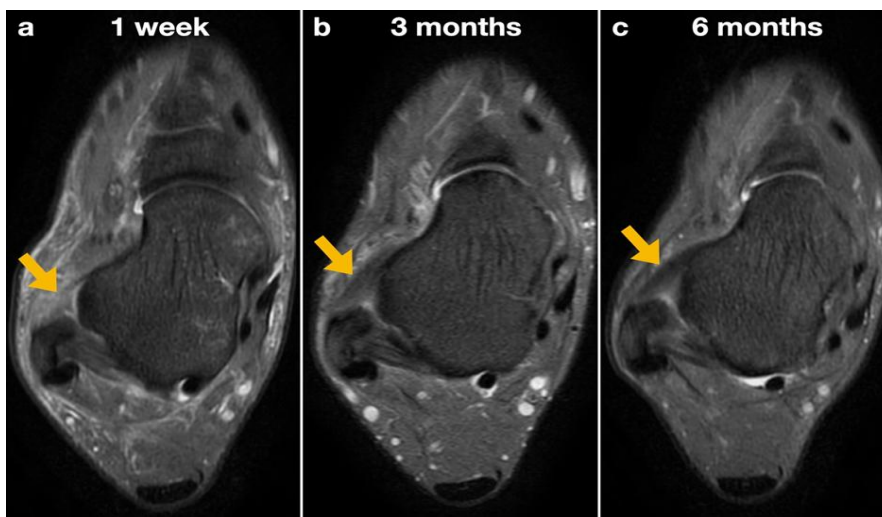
MRI of right ankle Proton Density Fat Saturation (PD-FS) sequence in axial view showed (a) ATFL (arrow) with high signal and full tear (grade 3) at origin end (fibula) at 1-week post-injury pre-injection (b) ATFL was thickened and showed reduced high signal (arrow), indicating healing with fibrosis at 3 months post-injection. (c) Further healing and reduced high signal of ATFL (arrow) with more conspicuous fibers at 6 months post-injection.
